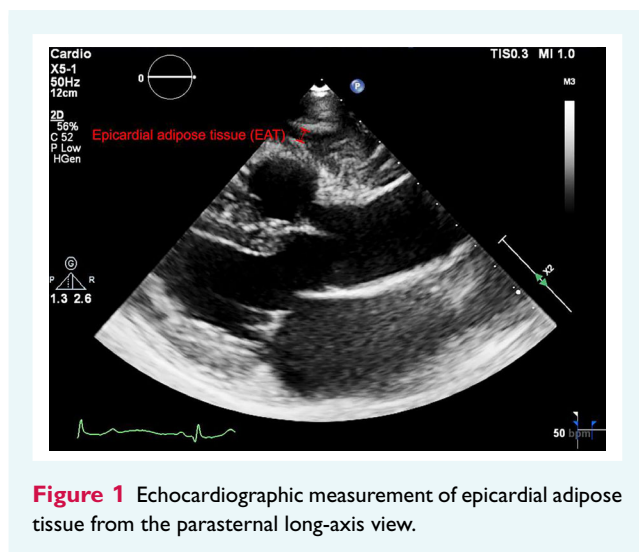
Echocardiographic measurement of epicardial adipose tissue from the parasternal long-axis view.
